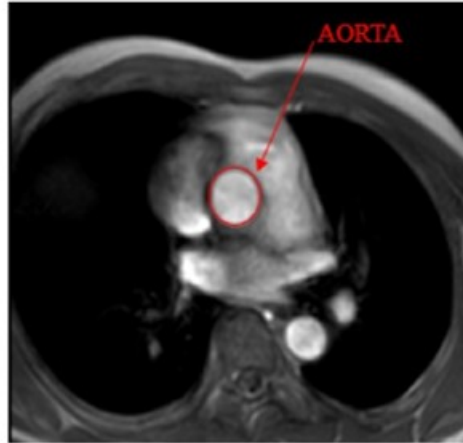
Aorta Phase Contrast MR image.
